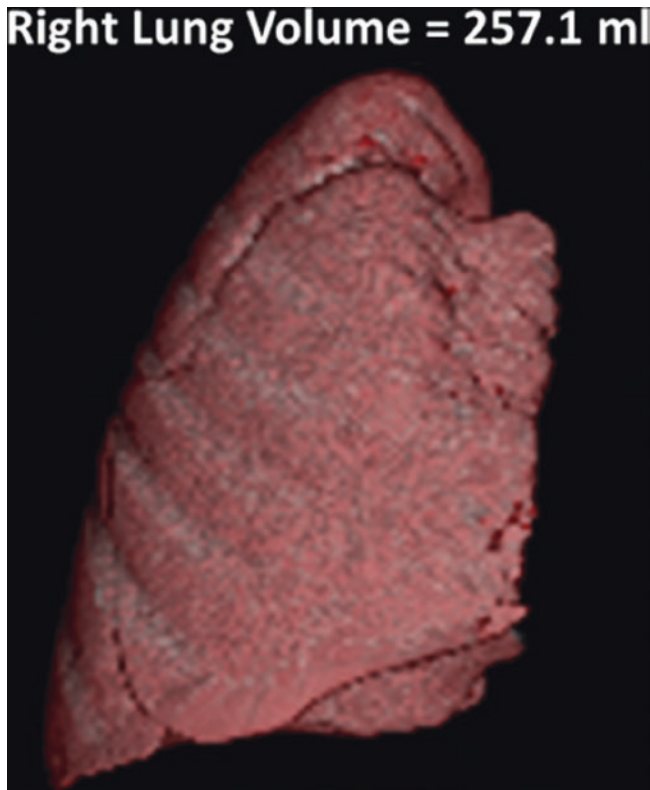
3D CT imaging evaluation of feasibility of the lung for organ donation. 3D volume-rendered CT image shows the right lung volume of 257.1 ml
